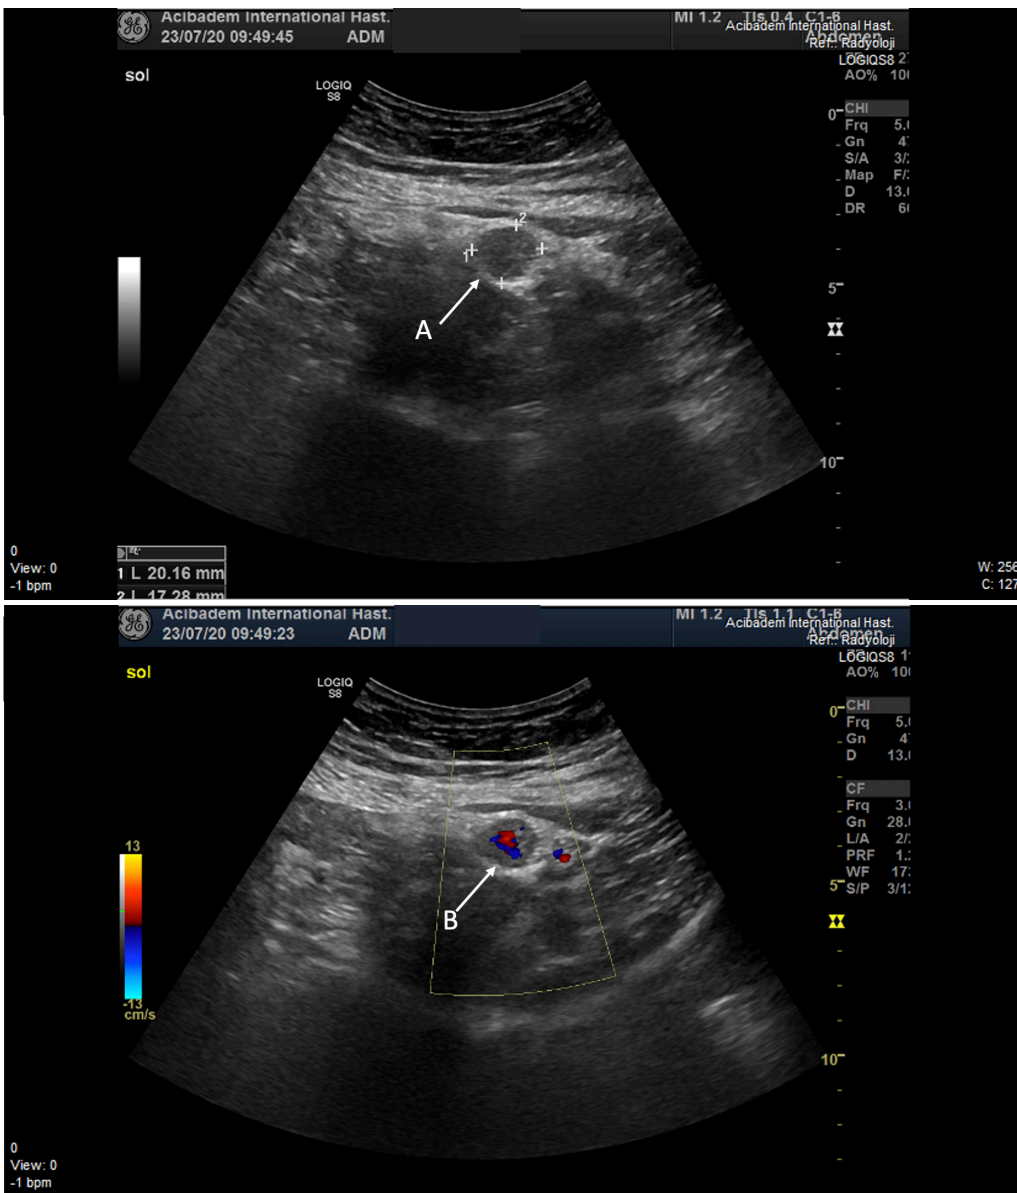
Ultrasound imaging. A: Abdominal ultrasound imaging indicating hypoechoic nodule. B: Vascularization of hypoechoic nodule on Doppler imaging.
